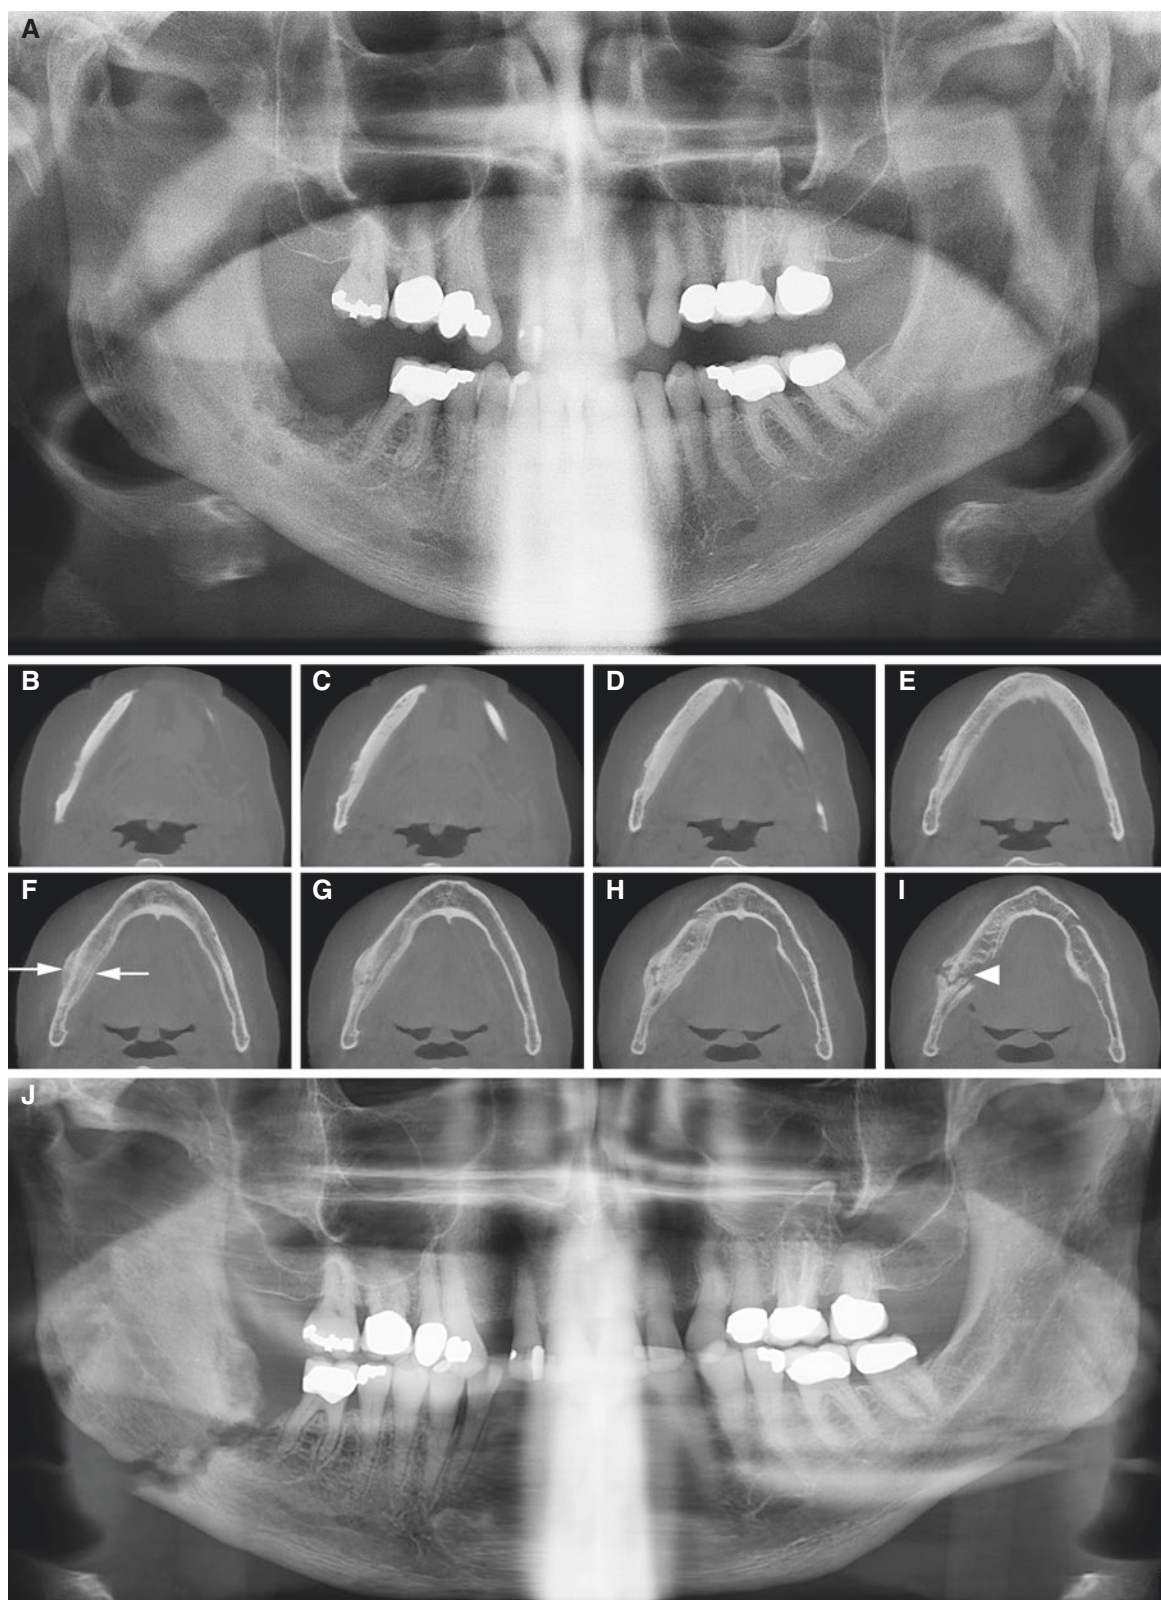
Mandibular fracture (pathologic); 73-year-old male on antiresorptive treatment with mandibular osteonecrosis. (A) Panoramic view shows destruction and sclerosis in the right mandible. (B, C, D, E, F, G, H, I) Axial CBCT images confirm destruction and sclerosis and additionally show periosteal bone apposition buccally and lingually
